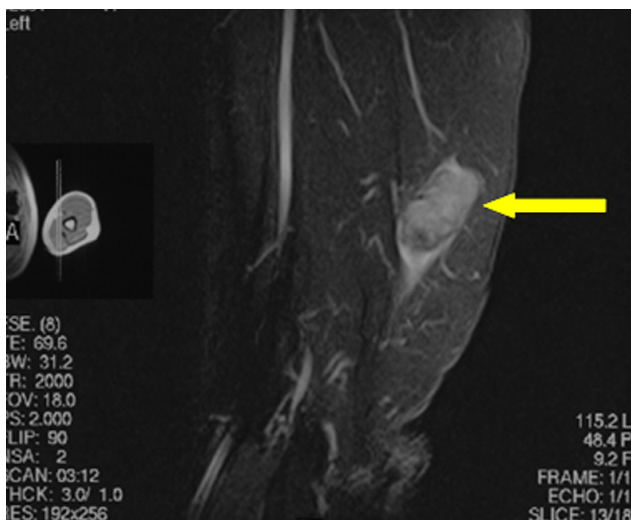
Magnetic resonance imaging (short tau inversion recovery sequence) shows enhanced, heterogeneous signal of lesion in left arm.
